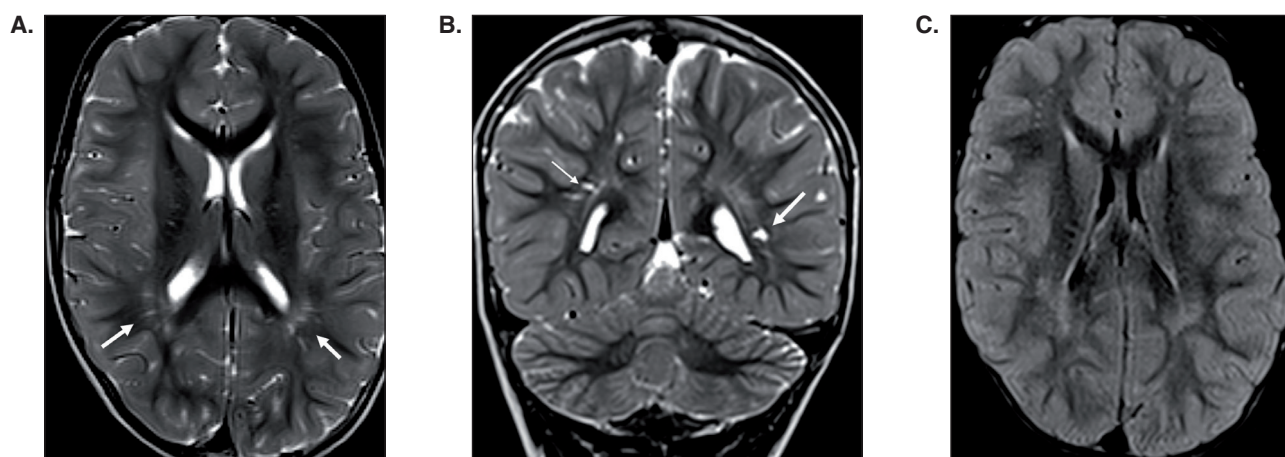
Axial T2-weighted (A), coronal T2-weighted (B), and axial T2 FLAIR (C) images show mildly enlarged perivascular spaces in the peritrigonal regions (arrows).
